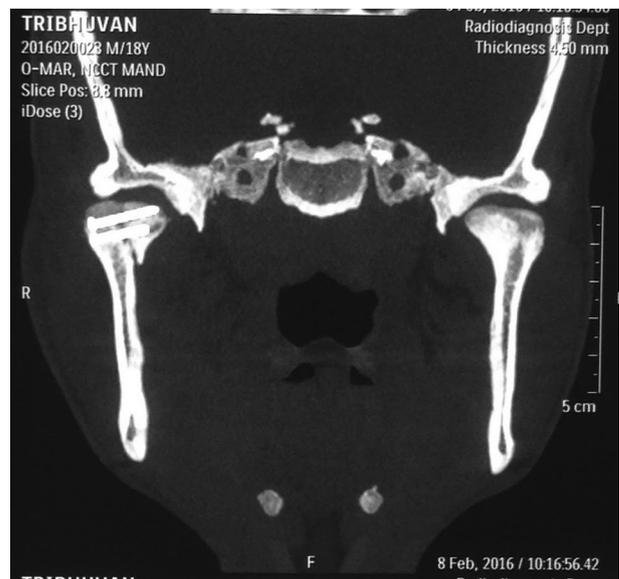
Post-op CT showing anatomically reduced medial fragment
